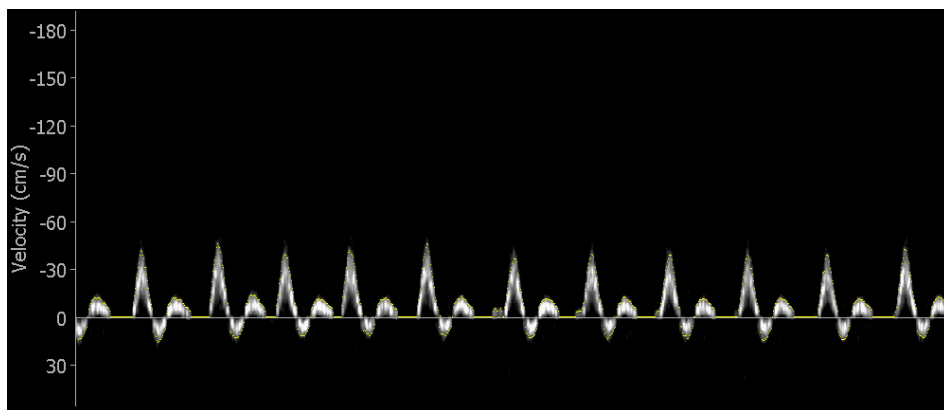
Doppler blood flow velocity range of interest.
